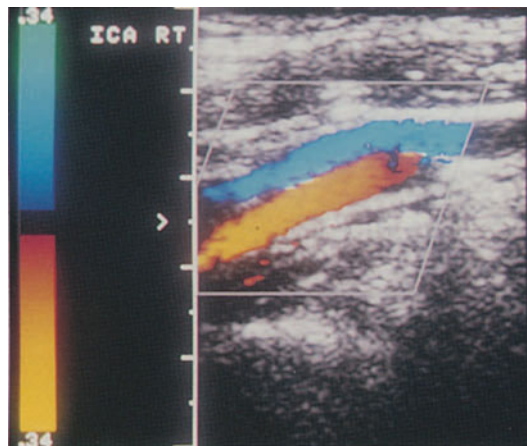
(left) Longitudinal sonogram: ICA (red) runs parallel to the internal jugular vein (blue, because of opposite flow direction)
